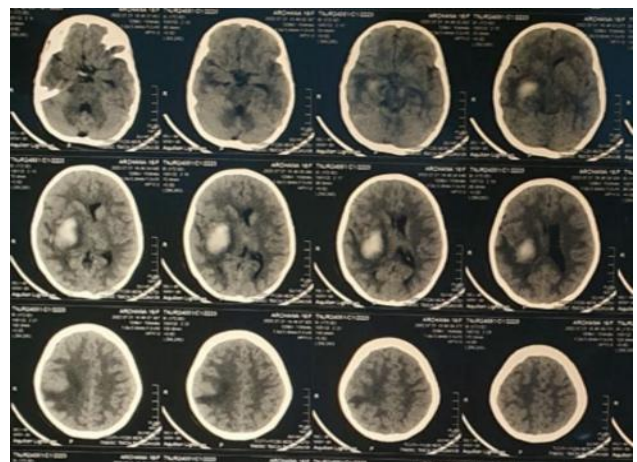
CT brain shows a gangliocapsular bleed which led to a 6 mm midline shift.
